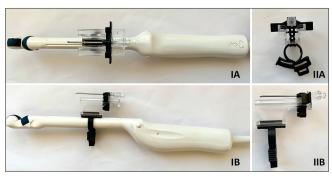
(i) ARIETTA 60 HITACHI diagnostic ultrasound system Biplanar tranrectal probe (CC41R1) installed with PRECISION POINT DEVICE (PrecisionPoint[™]-BXTAccelyon) and loaded with Coaxial biopsy needle - BARD Truguide 13-gauge × 7.8 cm (C1410A) (A) aerial view, (B) lateral view (II) PRECISION POINT DEVICE loaded with Coaxial biopsy needle (A) end-on view, (B) lateral view
